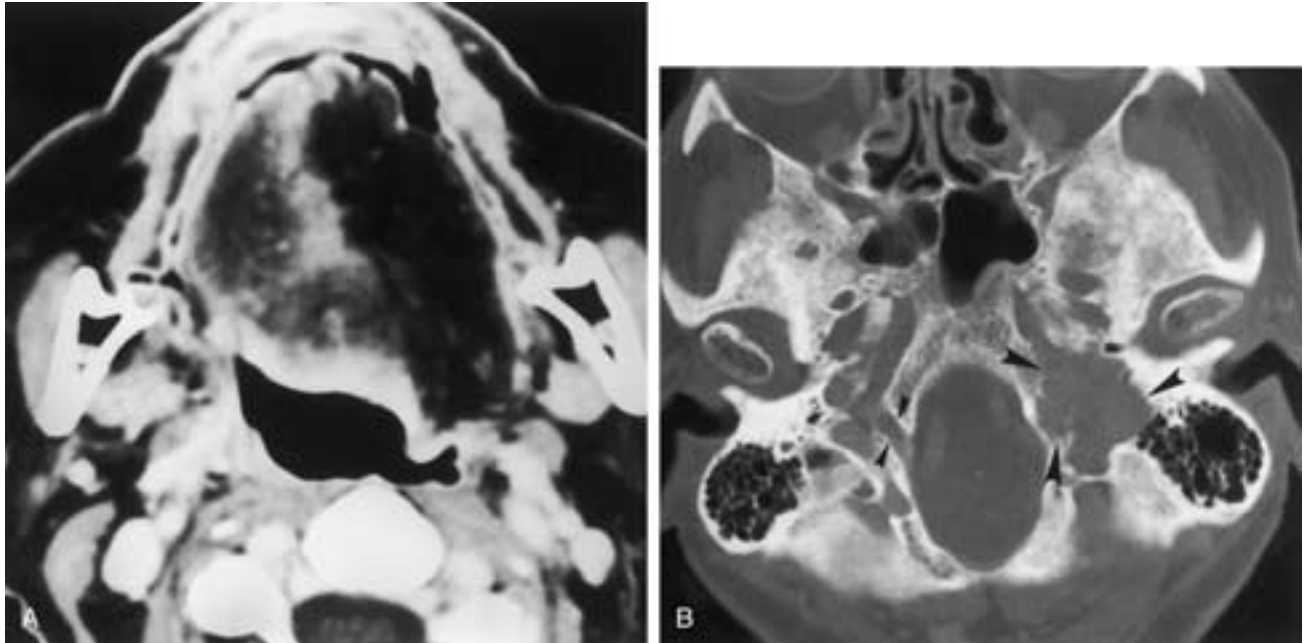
Long-standing chronic hypoglossal nerve denervation atrophy. A, Axial contrast-enhanced CT scan of the oral tongue reveals complete atrophy and fatty replacement of all of the left hemitongue muscular structures, both intrinsic and extrinsic. There is prolapse of the left hemitongue into the oropharynx, producing contour abnormality. B, Axial CT scan at the level of the hypoglossal canal with a bone window setting reveals extensive skull base destruction on the left (*large arrowheads*). The cortical margins of the normal right hypoglossal canal are well identified (*small arrowheads*). The large area of skull base destruction on the left (*large arrowheads*) clearly involves the region of the left hypoglossal canal. (From Smoker WRK. The hypoglossal nerve. *Neuroimag Clin North Am* 1993;3:193–206.)
